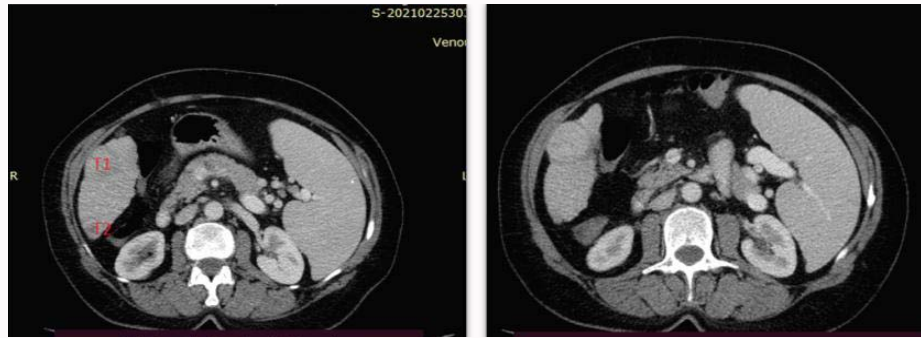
CT scan aspects of liver tumors.
